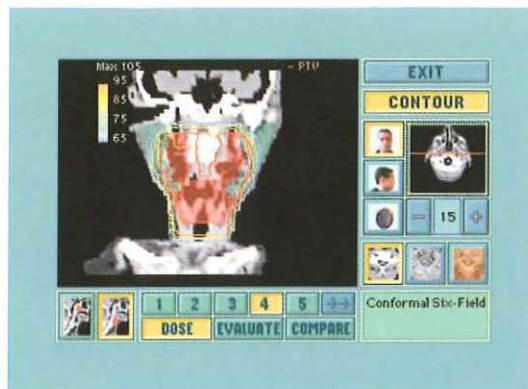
Screen of the "Radiation Therapy" module on CD-i. The image window shows a selected CT slice with the dose distribution belonging to the conformal radiotherapy technique of an early stage supraglottic larynx cancer.
